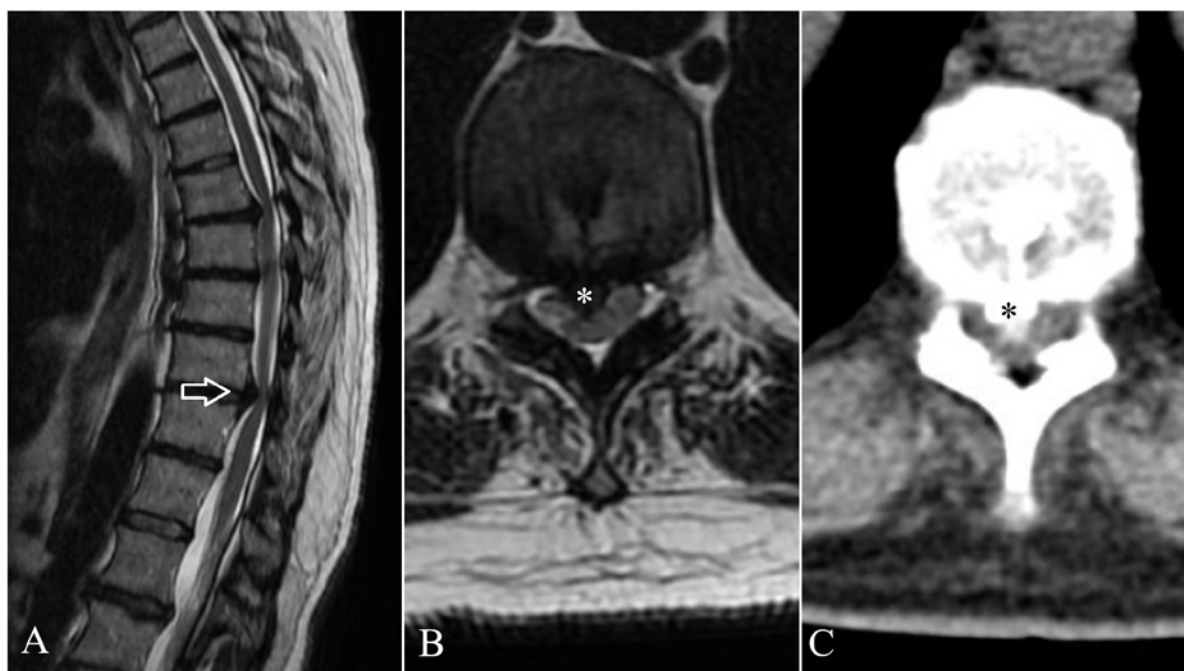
(A) Sagittal T2 weighted magnetic resonance imaging (MRI) image of the thoracic segment reveals T10-T11 intervertebral disc herniation with myelopathic signal (arrow); (B) axial T2 MRI and (C) computed tomography images show centrally displaced and calcified intervertebral disc with compression on the medulla (asterisk).
